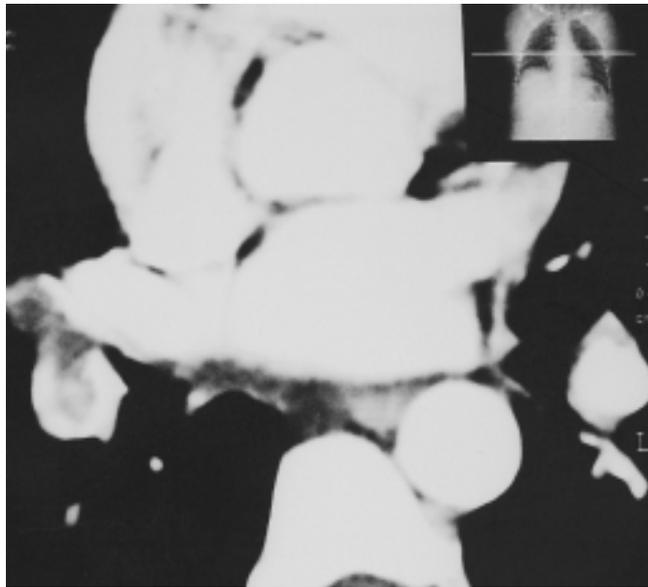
"CTA showing intra luminal filling defect in right descending pulmonary artery.
